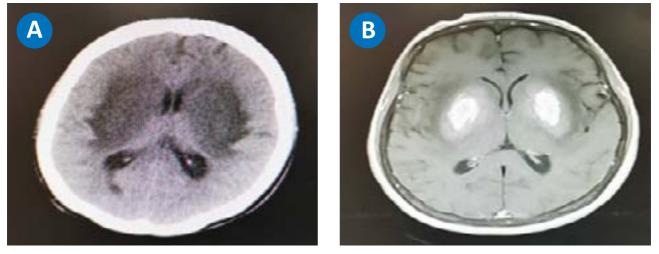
Figure A CT brain contrast revealed worsening bilateral basal ganglia hypodensities with involvement of the adjacent white matter and thalami. There was effacement of the adjacent cerebral sulci, frontal horns of both lateral ventricles and third ventricles. Figure B MRI of the brain (non-contrast) showed both globus pallidus demonstrated heterogenous hyper and hypointensity, involving of both putamina in lesser extends. Heterogenous avid enhancement of both globus pallidus and the peripheral enhancement in T2-weighted MRI
